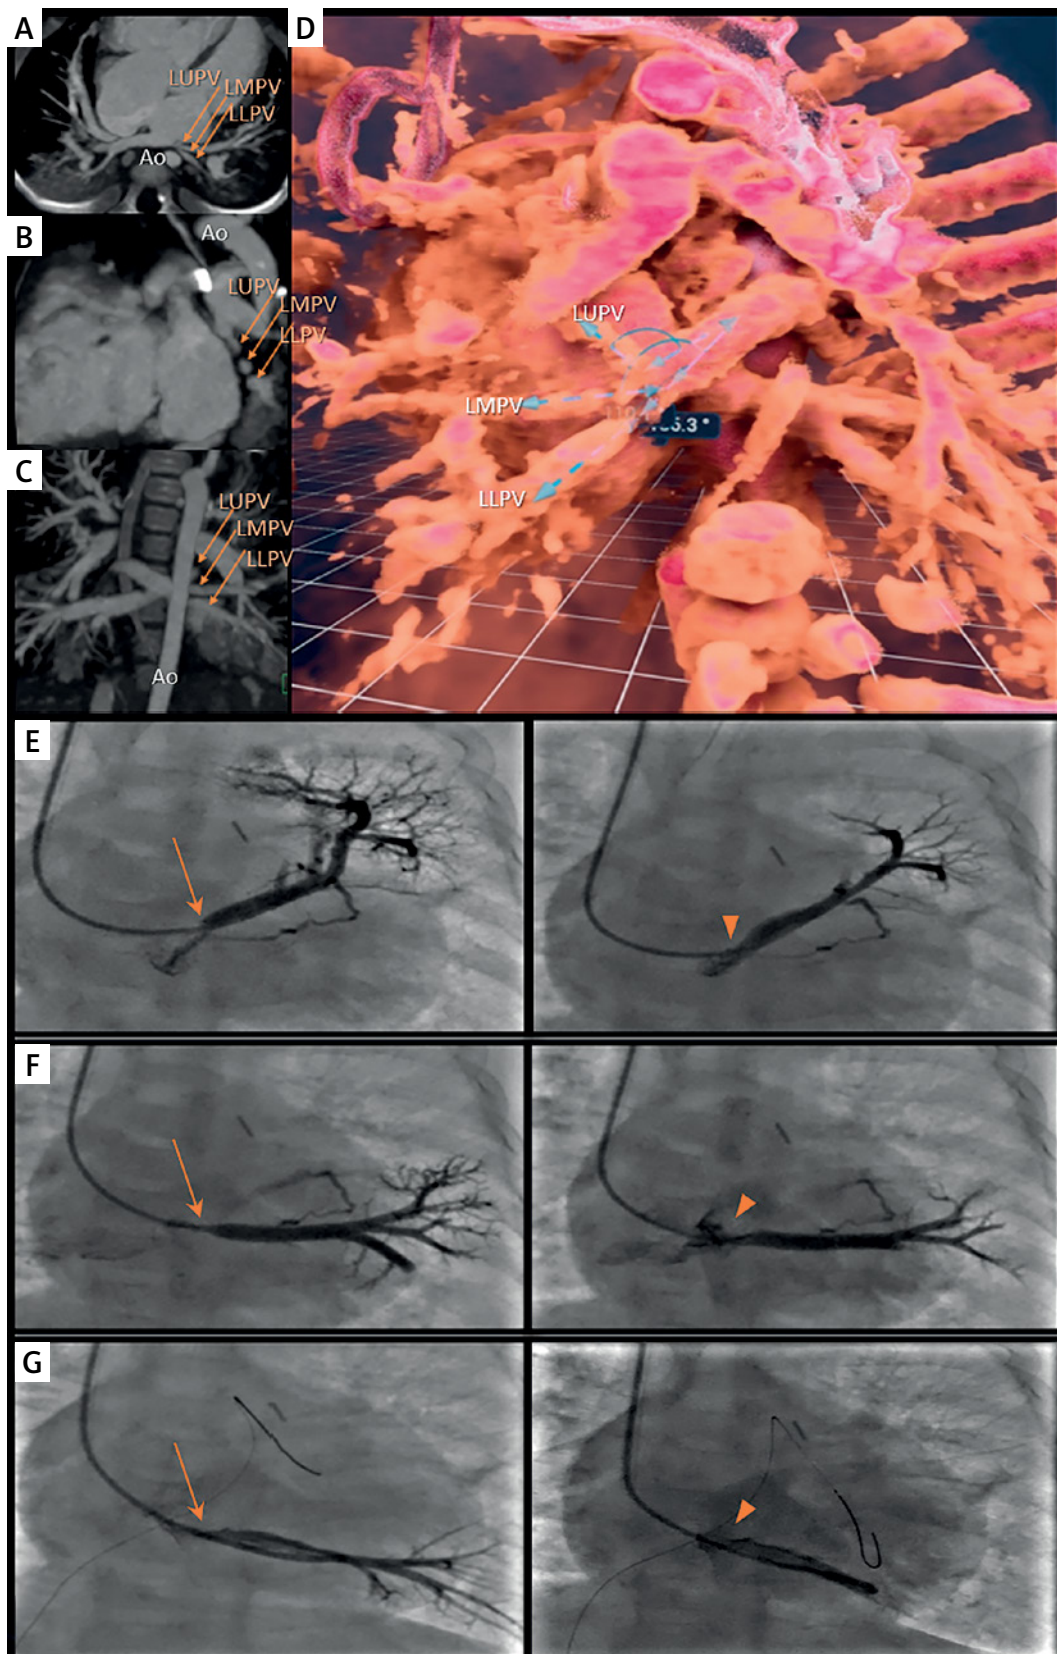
Multimodal imaging (CT, VR, 2D angiography) in the diagnostic and therapeutic process of patient 1. A – Axial view, B – sagittal view, C – coronal view of the CT scan. Arrows indicate the left upper pulmonary vein (LUPV), left middle pulmonary vein (LMPV), and left lower pulmonary vein (LLPV), respectively.
